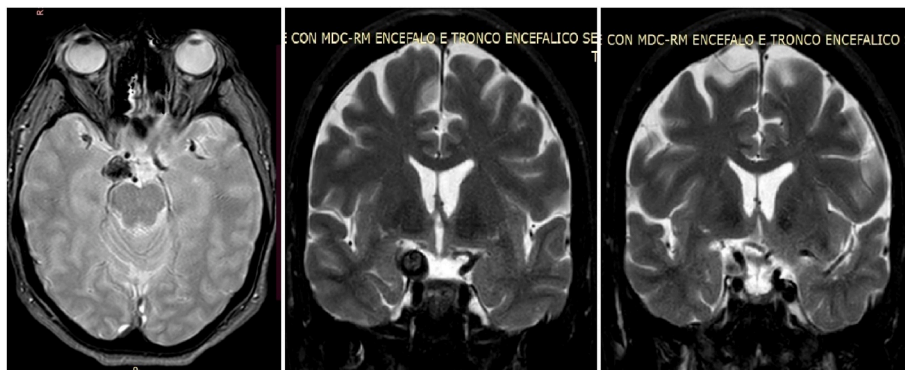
MR images reveal a large right P-ComA aneurysm about 1.5 cm in diameter, with areas of iso- and low-intensity on a T2-weighted image (left), Coronal T2-weighted image (right) clearly demonstrates the relationship between the aneurysm and the cavernous sinus.
